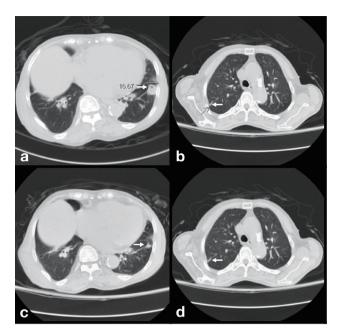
Chest computed tomography with contrast enhancement. Figures 2a and 2b, captured at the time of admission, showing pulmonary abscess formation in the left lower and right upper lungs. Figures 2c and 2d, captured at 1 month after the treatment, showing regression of the abscesses.
